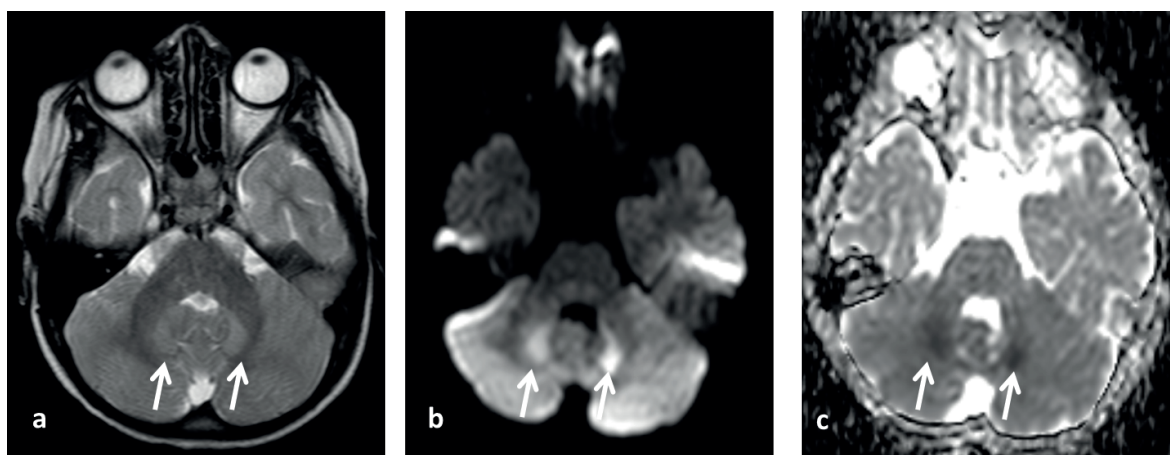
Magnetic resonance (MR) imaging of patient on day-3. T2-weighted axial image (a) demonstrated that the high signal intensity in dentate nuclei (arrows). B 1000-weighted (b) and ADC (c) images also showed that the diffusion restriction in the same areas (arrows).
